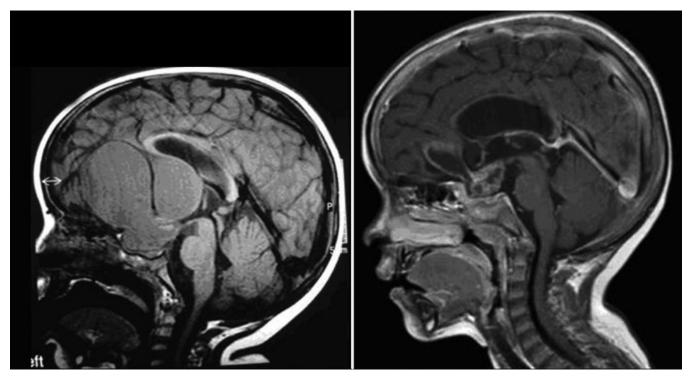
Left and Right: Sagittal T1-weighted enhanced MR images obtained before treatment of a cystic CP and the 4 years after the IFN α 2A treatment (5 cycles).
